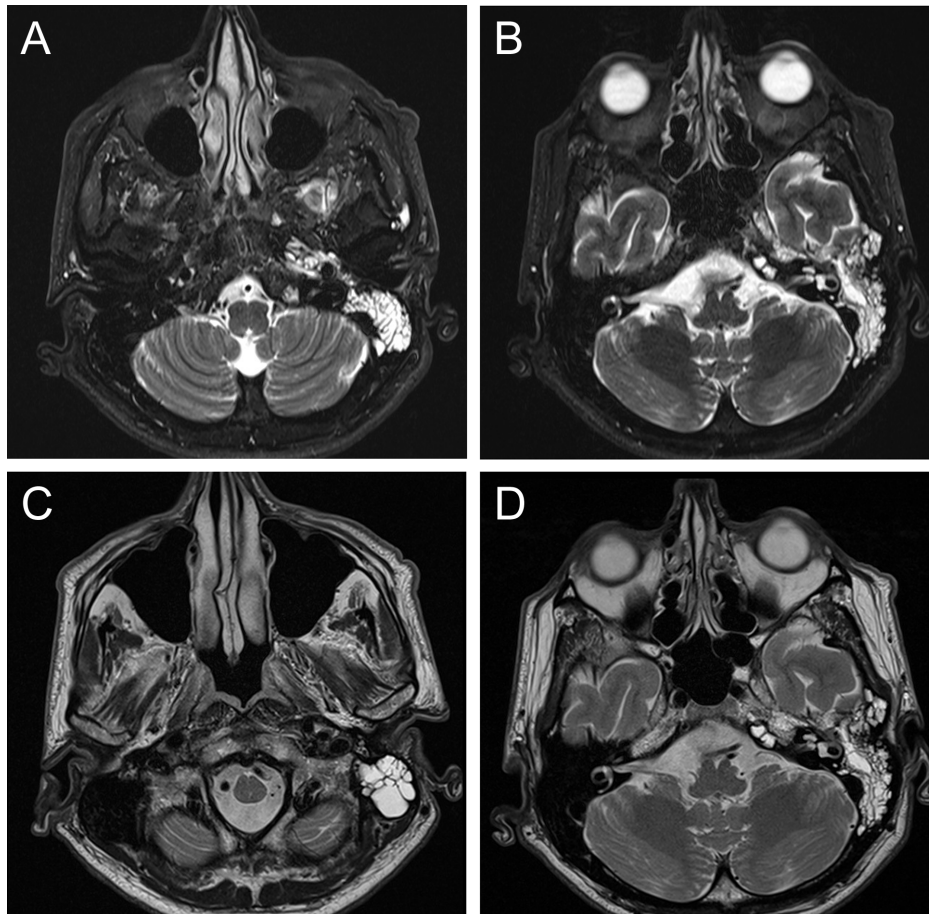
Axial T2-weighted (A, B) and T1-weighted magnetic resonance images (C, D) showing pre-operative scans of the temporal bones showing a tumor mass filling the middle ear space and fluid retention in the mastoid.
